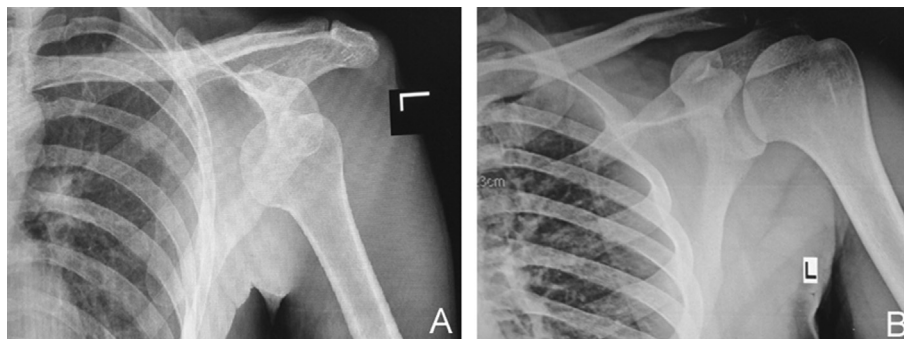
Radiographic evaluation of the dislocated shoulder joint, anteroposterior view (A). Post-reduction radiograph shows the head of humerus relocated into the glenoid fossa (B).
